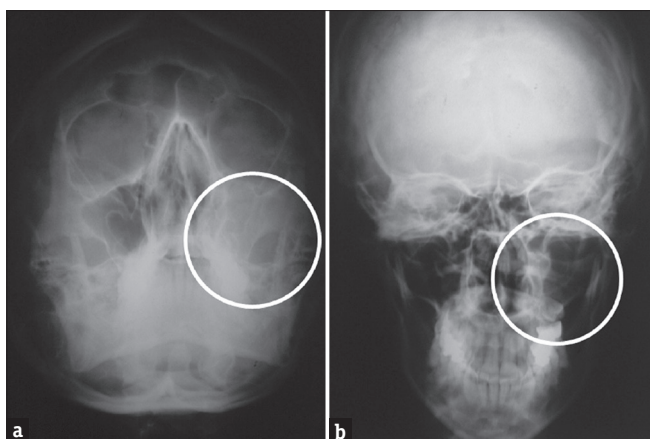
Post-operative x-ray skull (Posteroanterior view). (a and b) the white circles limit and highlight the opacity of the right maxillary sinus
